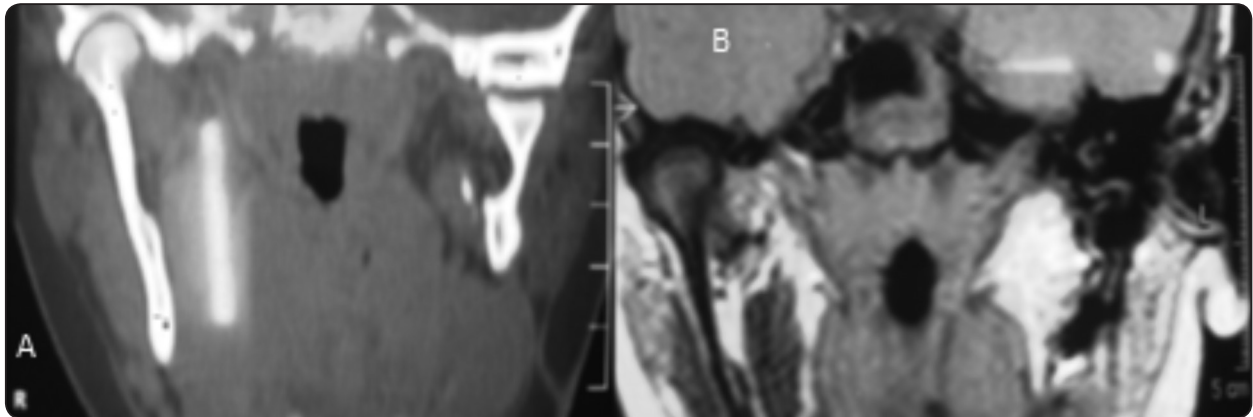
(A), CT coronal cut showing normal Rt. Joint and gap-arthroplasty of Lt. Joint. (B), MRI images of coronal cut showing normal disk position of Rt. Joint.
